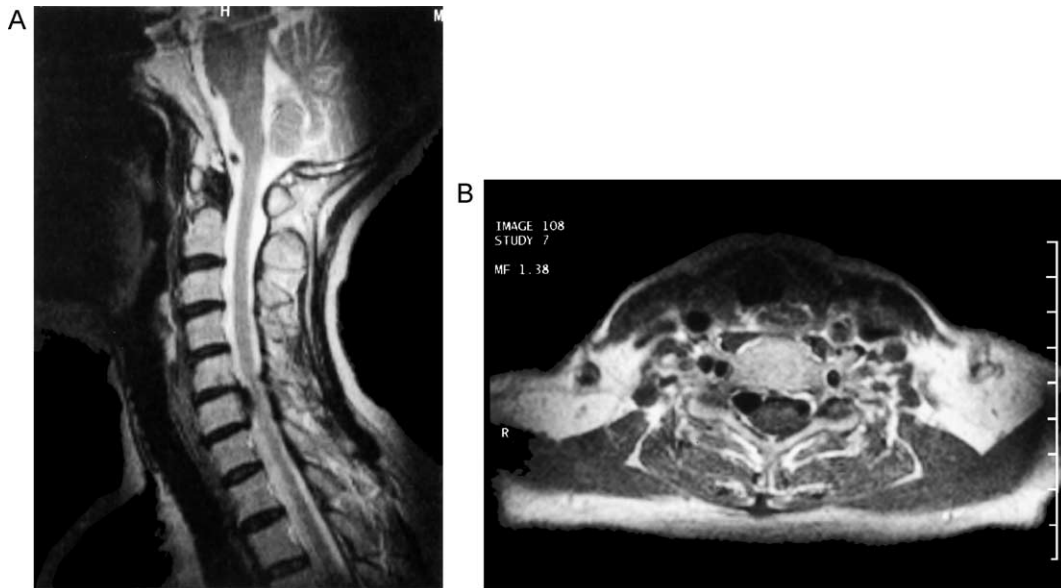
A, MRI (sagittal view), flow void is shown at C6 level. B, MRI (axial view), flow void mass compresses spinal cord.
